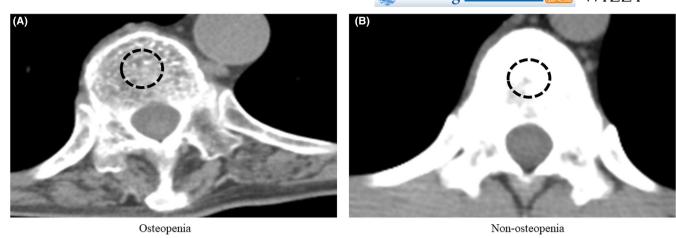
We measured in the trabecular bone by calculating the average pixel density within a circle of the mid-vertebral core at the bottom of 11th thoracic vertebra on preoperative plain computed tomography. A. Osteopenia and B. Non-osteopenia
